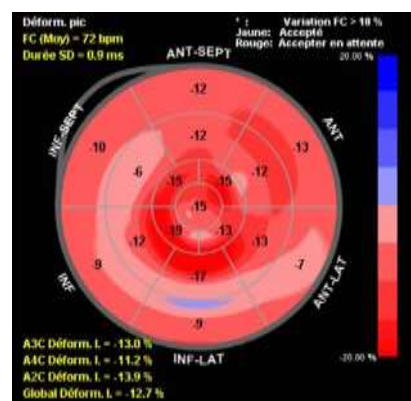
Echocardiographic strain evaluation
